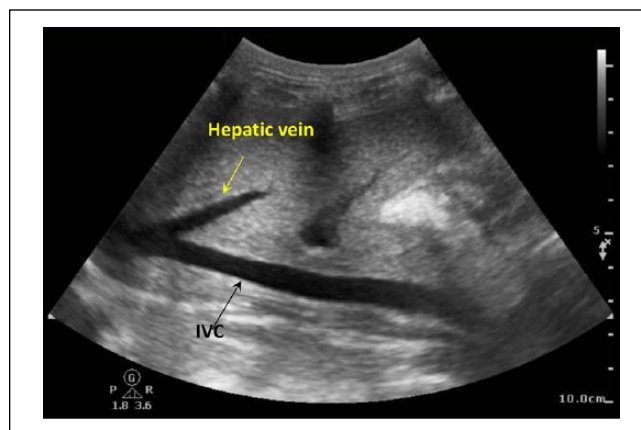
B-mode ultrasound images showing IVC and hepatic vein. IVC = inferior vena cava.
